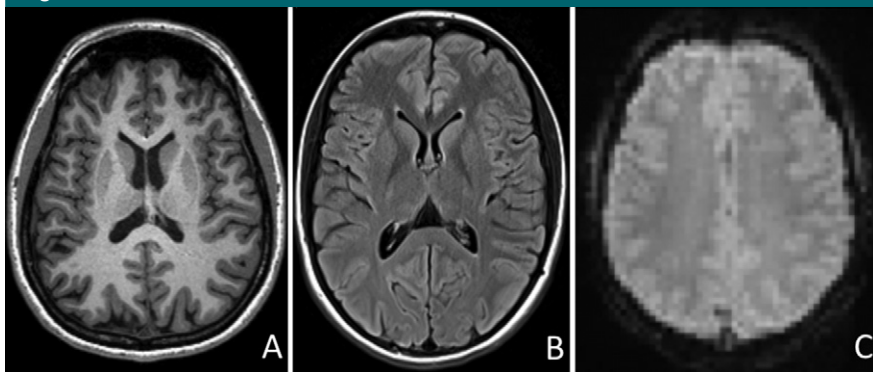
MR images obtained as part of the neurologic MR imaging protocol. *A*, T1-weighted 3D magnetization-prepared rapid acquisition gradient-echo sequence. *B*, Two-dimensional fluid-attenuated inversion recovery sequence. *C*, Two-dimensional gradient-recalled-echo echo-planar imaging blood oxygen level-dependent sequence (for resting-state functional MR imaging).
